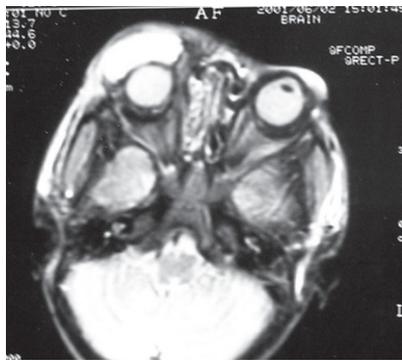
MRI (T2WI, axial) showing CSF collection in right eyelid. The eyeball is normal in its position.
